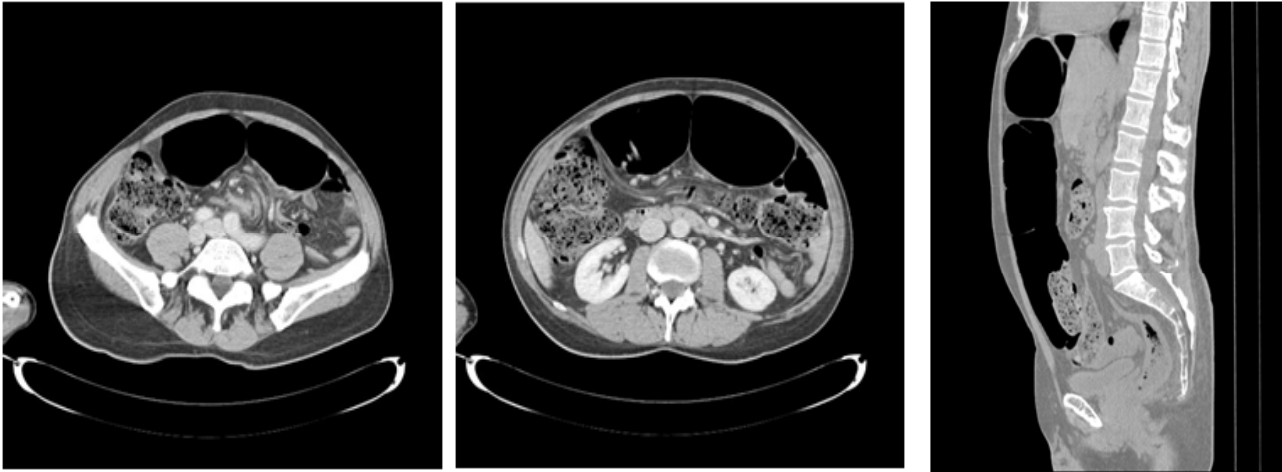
a-b-c. Axial and sagittal CT of the abdomen showing a gaseous overdistension of the sigma without free air or fluid in abdomen: «whirl sign» (arrow) with ectasia of mesenteric vessels. Sagittal reconstruction confirmed the overdistension of the sigma dislocated anteriorly
